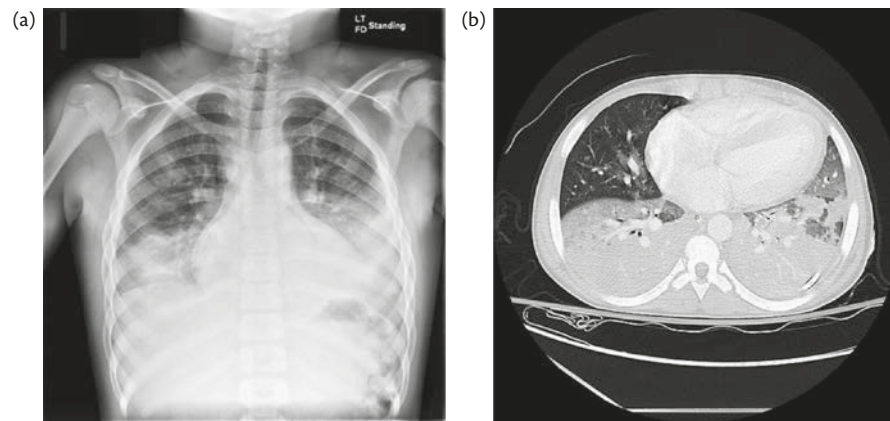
A 14-year-old boy with sickle cell disease and acute chest syndrome. (a) Chest X-ray bilbasilar infiltrates and a moderate-sized left pleural effusion. (b) Chest CT of the same patient showing multifocal bilateral consolidations.
